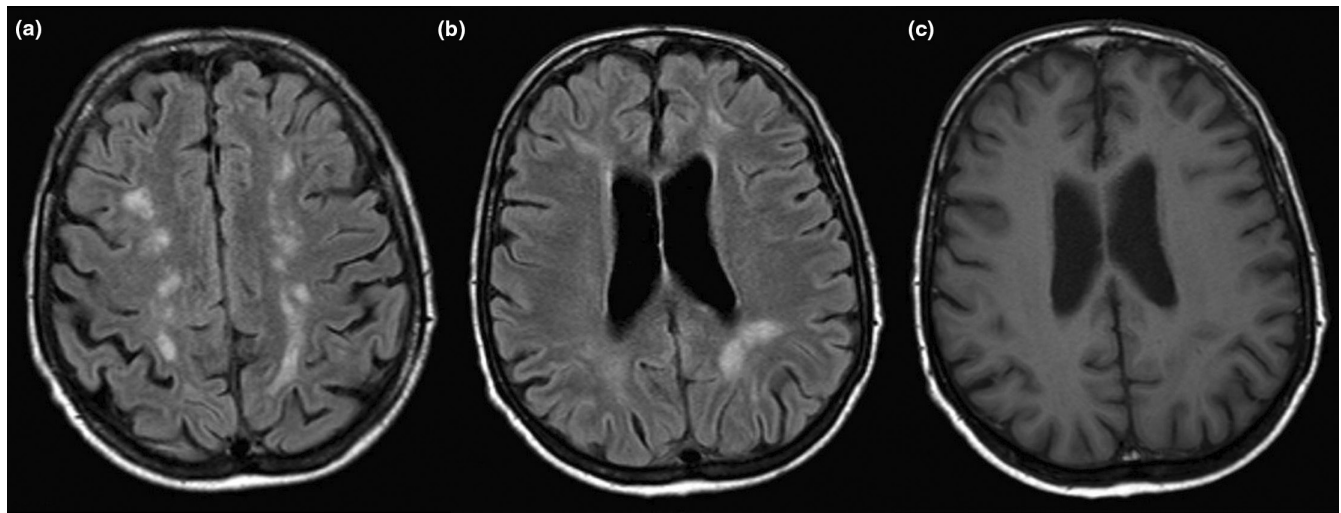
Case #3 brain magnetic resonance imaging. (a, b) Axial T2-fluid attenuated inversion recovery images of the brain showing bilateral multiple subcortical hyperintense white matter lesions sparing the “U” fibers, prevalent on the left hemisphere, interpreted as signs of demyelinating/inflammatory disease. (c) Axial T1 contrast-based imaging showing no contrast enhancement of lesions.
